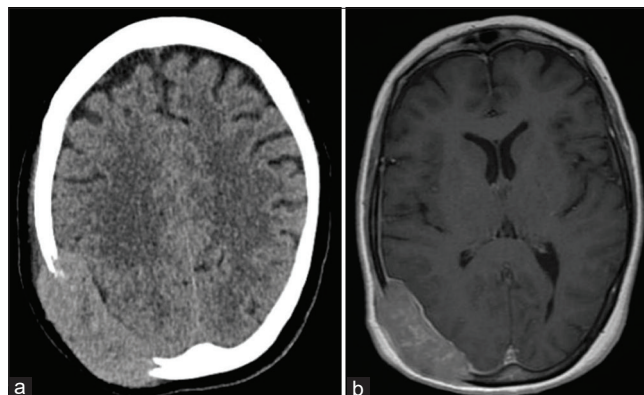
Computed tomography head demonstrating a large expansile transcalvarial lesion centered at the right occipital convexity measuring approximately 7.1×2.3 cm transaxially (a) with resultant sulcal effacement of the subject temporal, parietal, and occipital lobes and expansion into the adjacent scalp soft tissues. Magnetic resonance imaging of the mass is also demonstrated (b).
